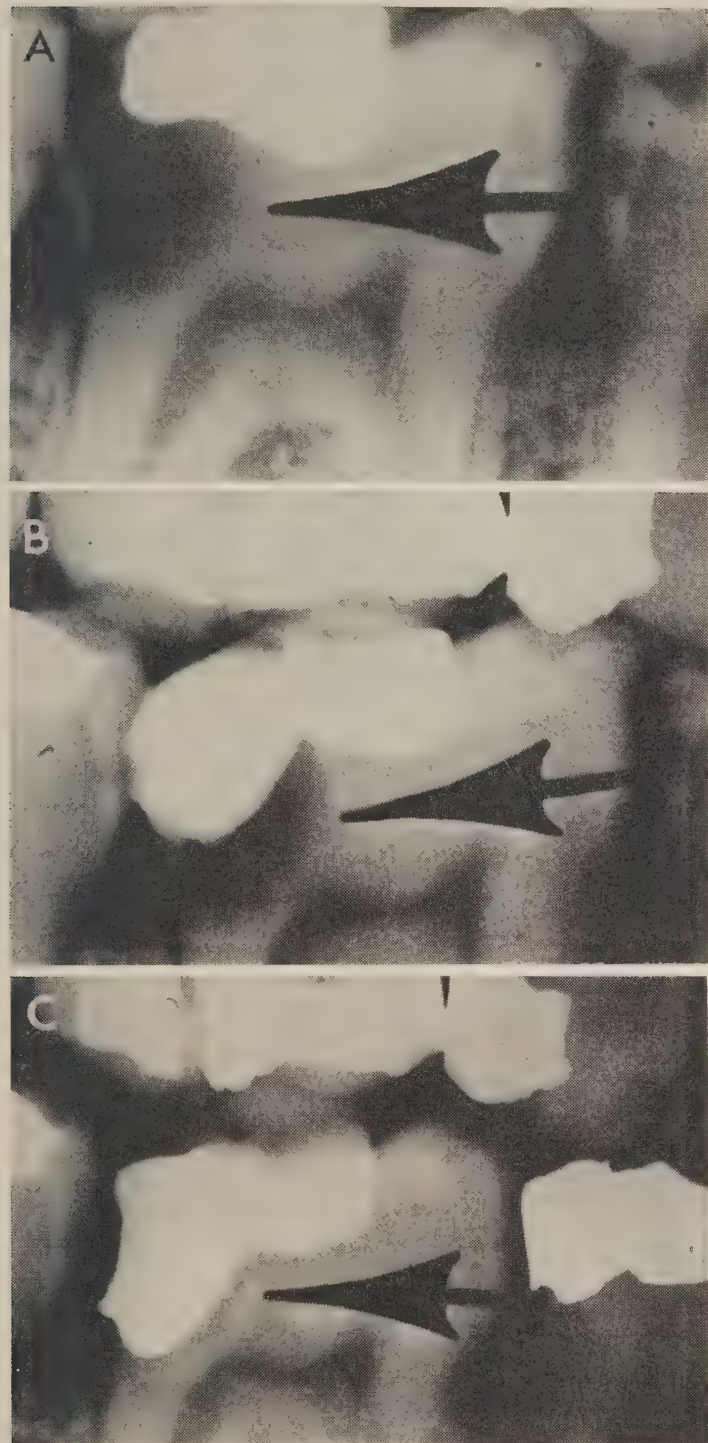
A, radiograph showing a deep carious lesion in the mandibular right first molar of a 15 year old patient. B, the same tooth three months after indirect pulp capping. There is no apparent change. C, the same tooth four months after retreatment. Arrow points to radiopaque area of apparent remineralization.
